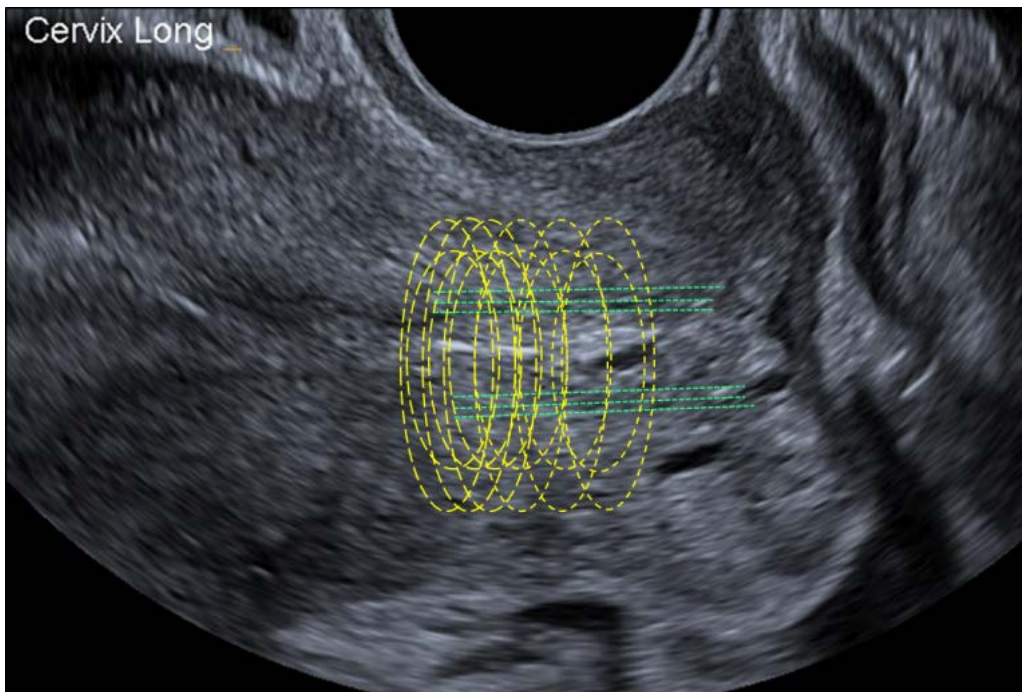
Ultrasound image of the uterine cervix demonstrating the central layer of smooth muscle fibres running parallel to the cervical canal and the circumferential layer of smooth muscle and collagenous fibres where the ROI is placed for SWE sampling.
